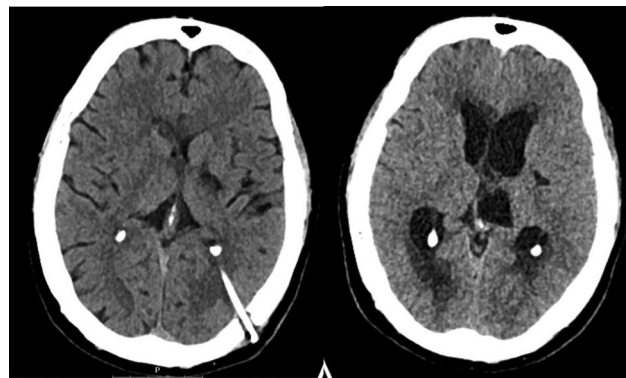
Pre- (right) and post- (left) operation (OP) computed tomography (CT) scan, showing the resolution of the lateral ventricles hydrocephalus.
